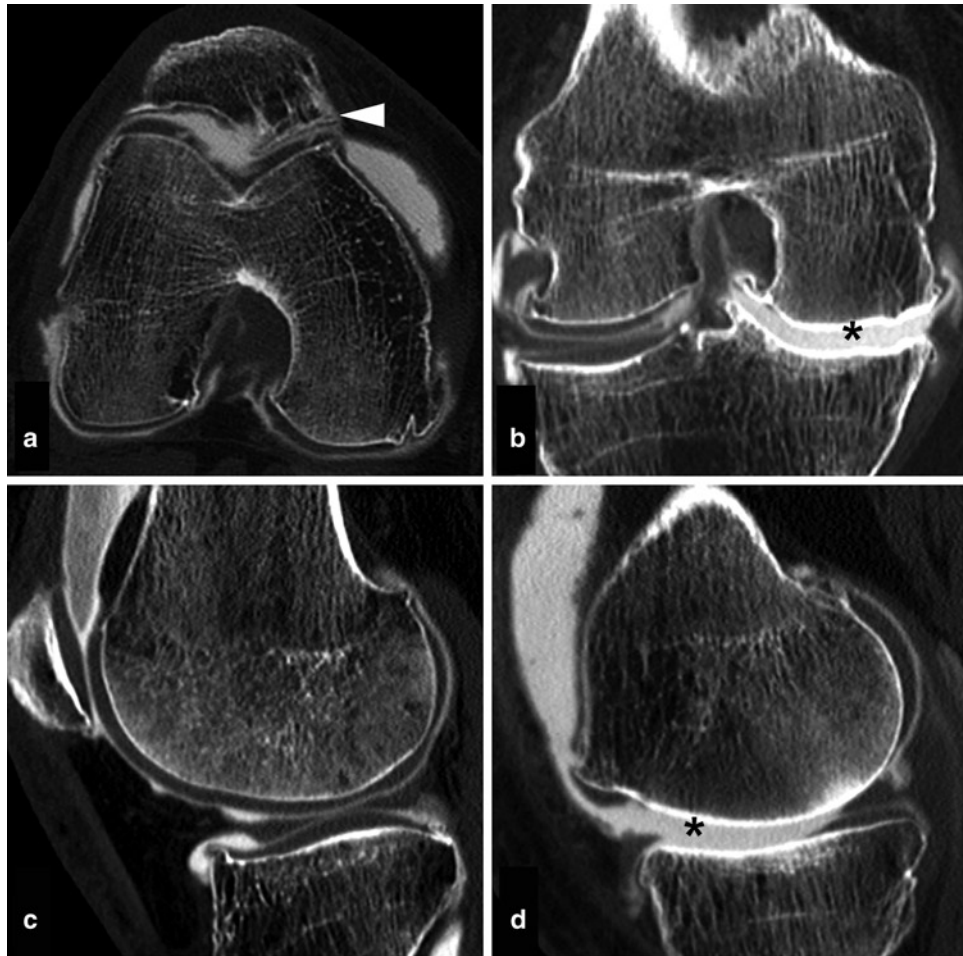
(a–d) Preoperative computed tomographic (CT) arthrography of a 72-year-old woman with bi-compartmental osteoarthritis. (a) Axial reformat showing the femoro-patellar osteoarthritis, with cartilage loss and osteophytes (*arrowhead*). (b) Coronal and (c, d) sagittal reformats
